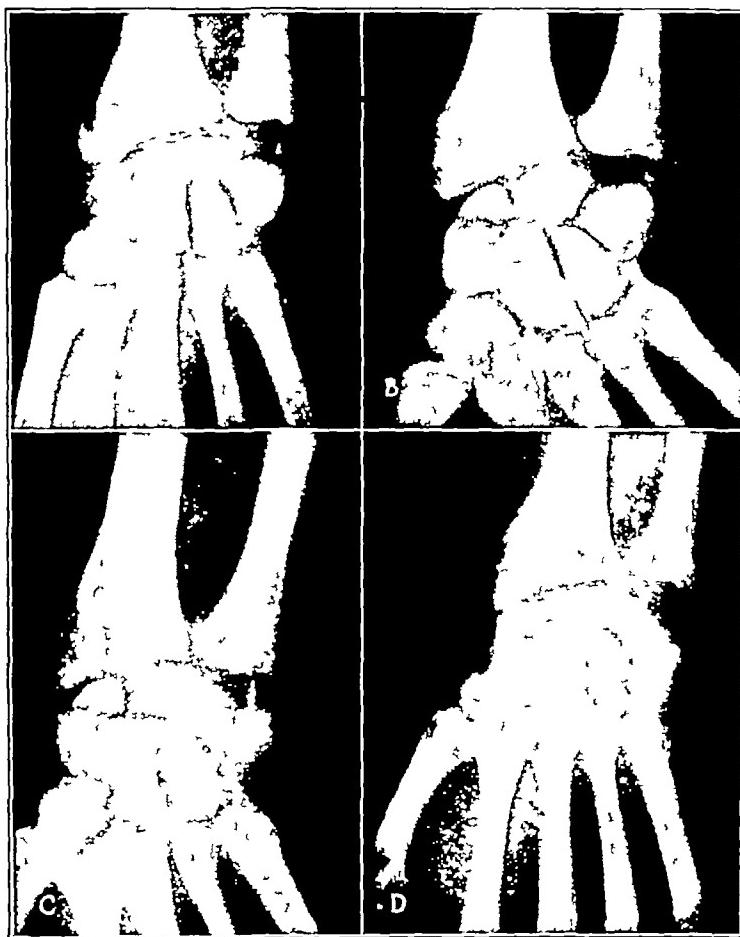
(case 4).—*A*, roentgenogram taken eleven days after injury, showing fracture across the proximal pole with dislocation of the upper fragment. There is also a fracture of the lower outer end of the radius and a fracture of the styloid process of the ulna. *B*, reduction of the fractured scaphoid. *C*, on October 16, seven weeks after the injury, the proximal fragment is dense and sclerotic, indicative of avascular necrosis of the bone. *D*, the proximal fragment excised and motion started.
